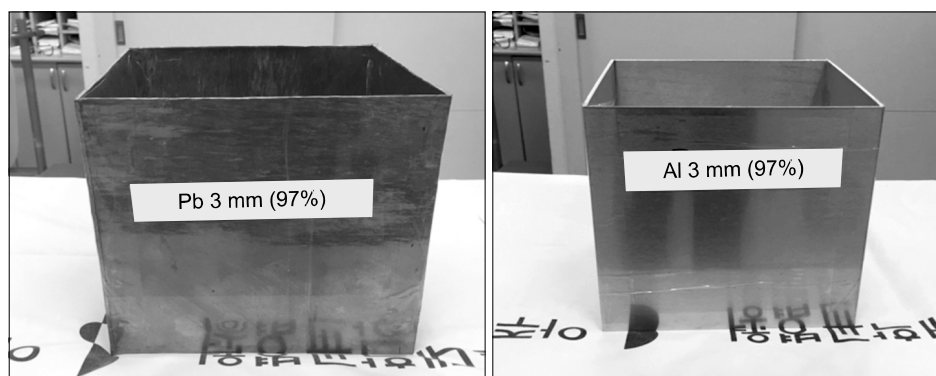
3-mm-thick Pb (x-ray tube shield) and 3-mm-thick Al (x-ray tube double shield).
